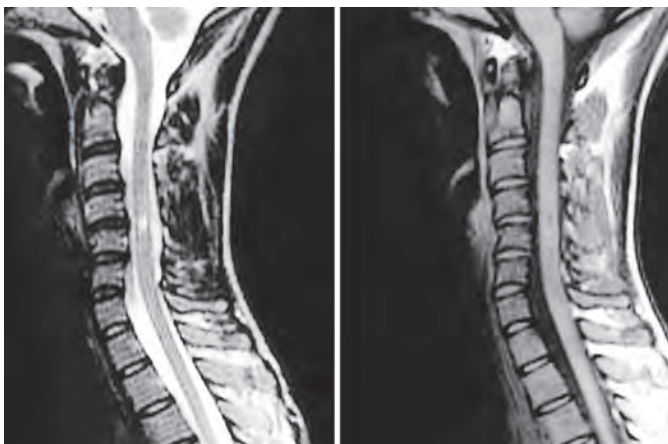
MRI (T2-weighted images) showing straightening of the cervical spine from C1 to C4
